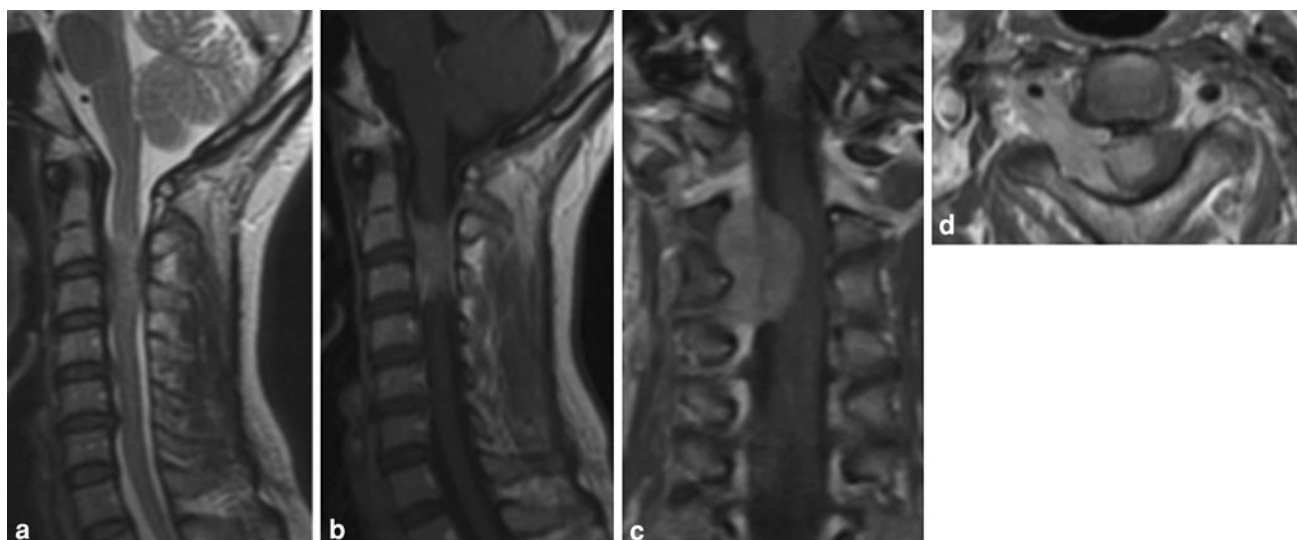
Preoperative MR images. a Sagittal T2-weighted image showing a T2 iso-high intensity area at the C2–3 levels. Axial view of the MRI at the C4/5, C5 vertebral, and C5/6 levels. Sagittal (b), coronal (c), and axial (d) Gd-DTPA enhanced T1-weighted images
